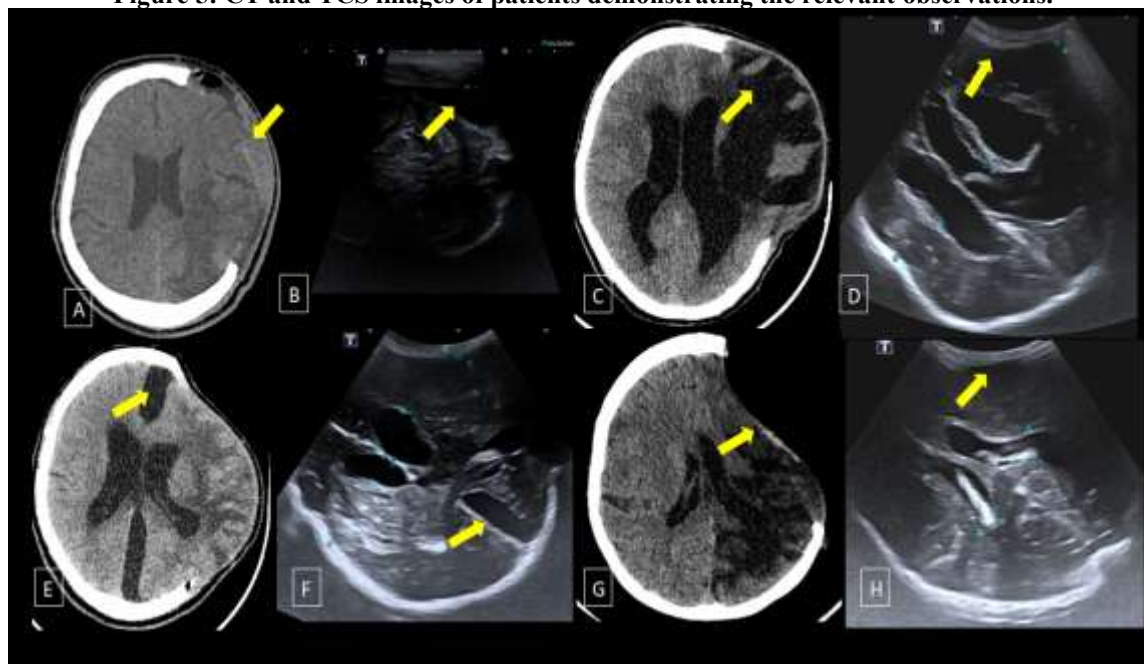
Images A & B demonstrate a crescent shaped subgaleal collection (yellow arrow) along the left frontal convexity on the CT. Corresponding TCS image with a high frequency probe shows an anechoic collection (yellow arrow). Although it appeared isodense on CT, we could not demonstrate any debris within this collection on TCS.
